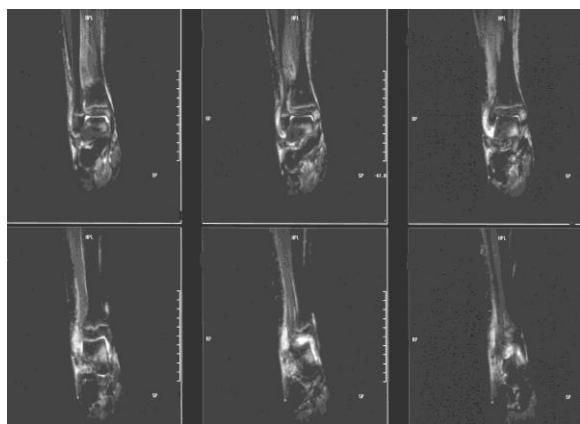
A 12-year-old girl stumbled and fell down the stairs injuring her right ankle. Due to the severity of the local symptoms and signs a MRI was performed 5 weeks post-injury. Short tau inversion recovery images showed bone bruising of the talus and medial malleolus as well as fluid signal more pronounced around the talus and in the lateral collateral ankle ligament.
